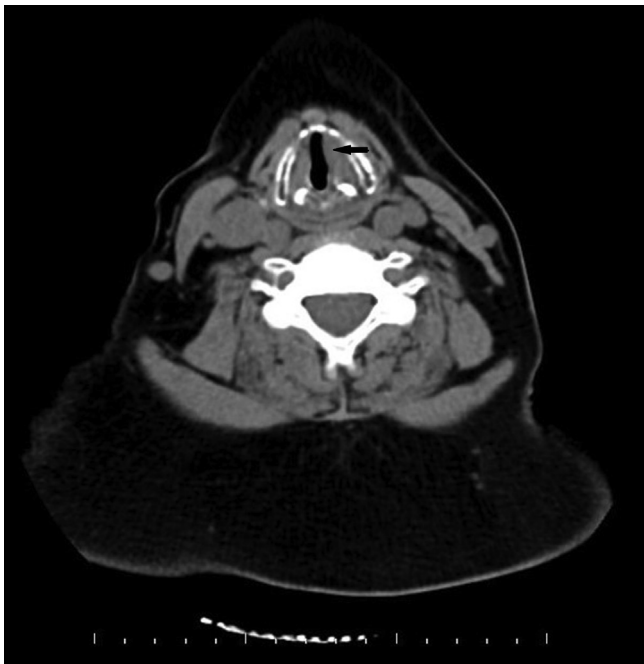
Axial CT showed thickness around left vocal cord. (Black arrow).
